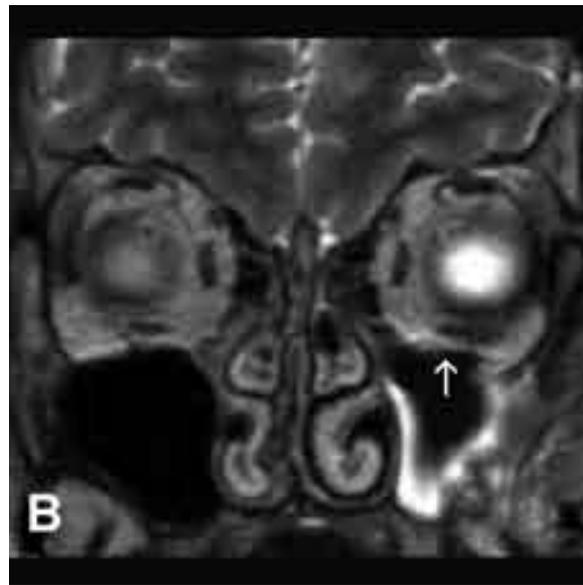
Patient R.A. a: CT MPR in the frontal plane: titanium mesh reconstructed bone defect in the orbital floor well visible (arrow), b: MRI T2-weighted image: titanium implant as a small area of metal-artifacts in the orbital floor (arrow).
